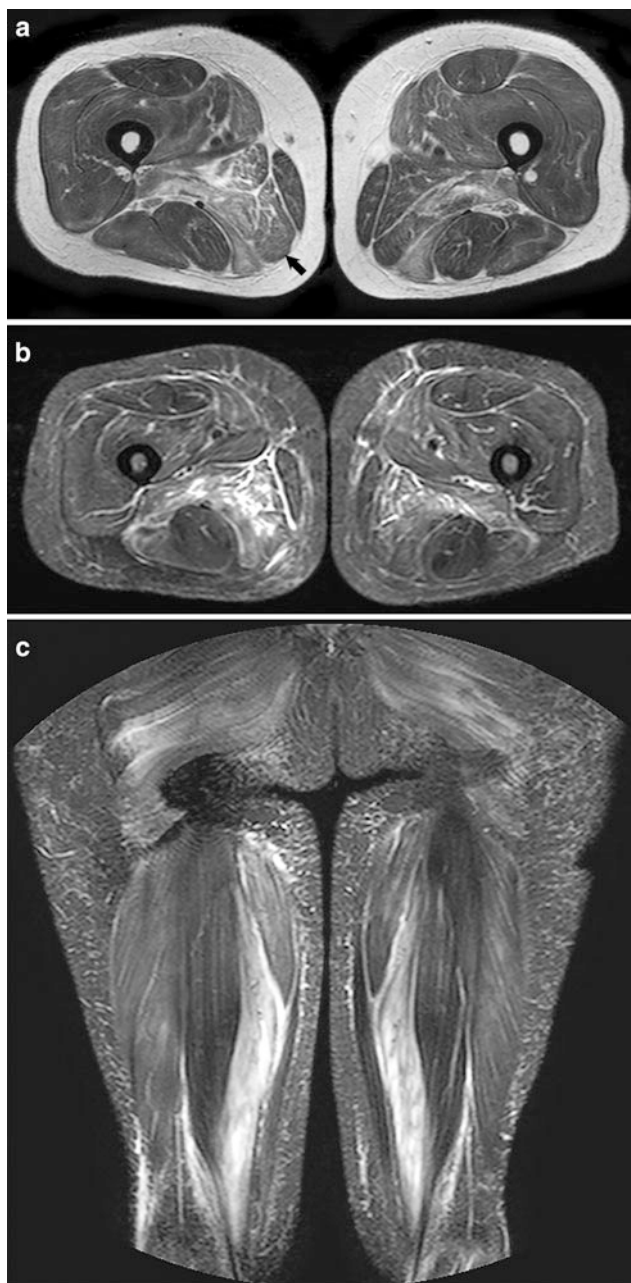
a Axial T2-weighted images (without fat suppression) of the thigh in a patient with necrotizing myopathy with hyperintensities of preferentially the dorsomedial compartment (*arrow*) and fascia b Axial STIR images of the thigh of the same patient as in Fig. 5a c Coronal STIR images of the same patient as in Fig. 6a
